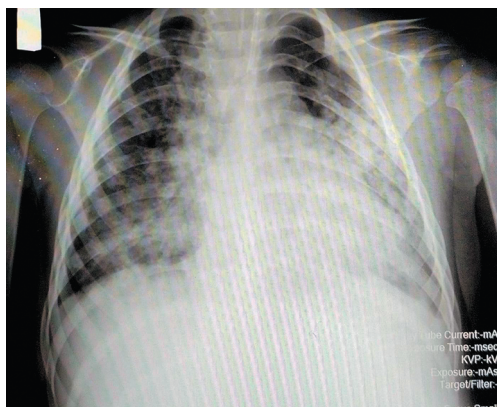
Chest radiography (7th day of hospitalization) (photo from the authors' personal archive)
